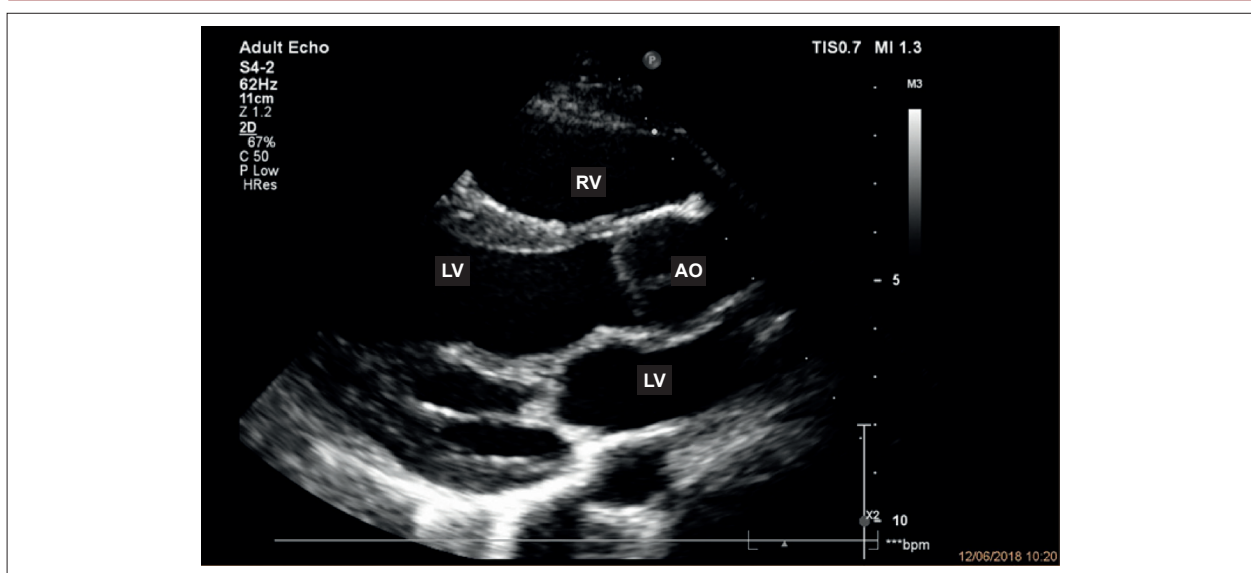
Parasternal longitudinal view evidencing mitral valve thickening and discrete aortic valve prolapse. RV: right ventricle; LV: left ventricle; AO: aorta; LV — left ventricle.
